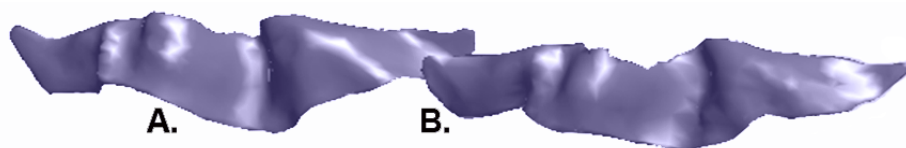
An example of the results from a registration-based segmentation of CS from longitudinal MR images. An atlas is created for each subject based on an automatic segmentation. A) Segmentation from BrainVisa. B) Registration-based segmentation of the same image.
